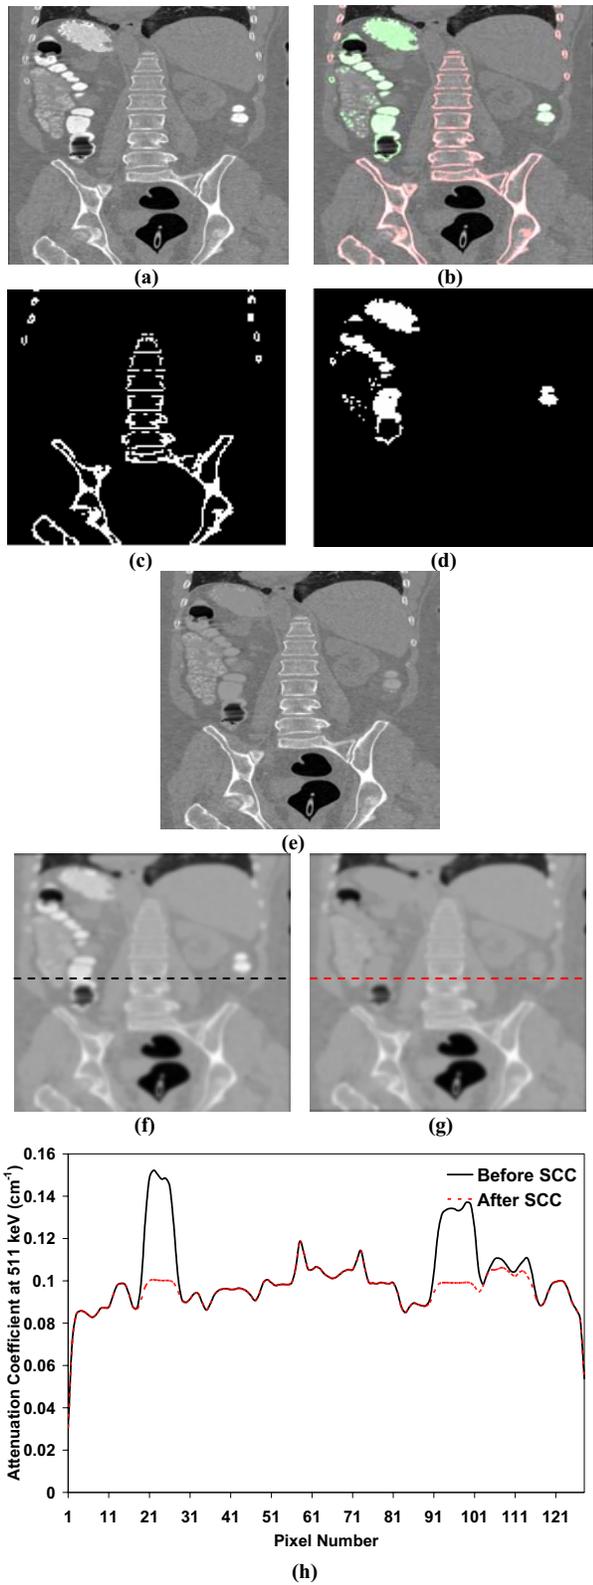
Original contrast enhanced CT image (a), segmented CT image (b), bone objects (c), contrast agent objects (d), original contrast enhanced CT image after applying SCC to the regions segmented as containing contrast agent (e), generated μ map from original CT (f), and generated μ map after SCC (g). Horizontal profiles (position shown in f-g) through generated attenuation maps before and after applying SCC (h).
